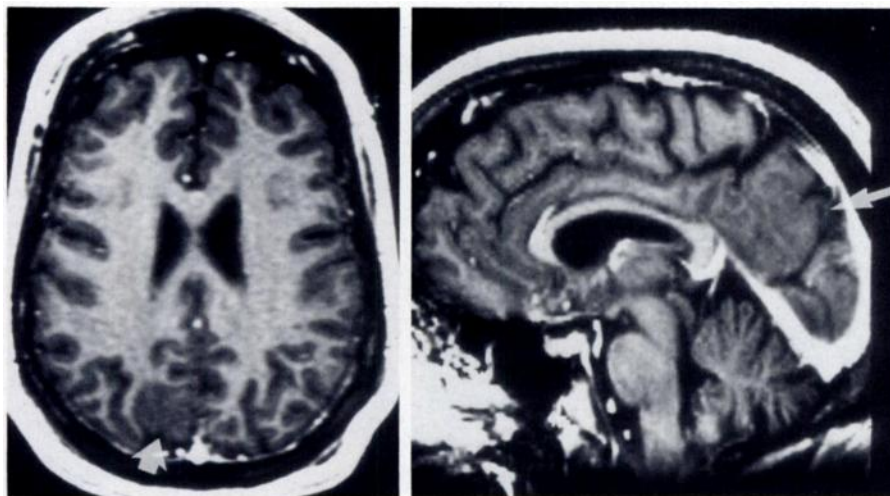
Cortical dysplasia in a 44-year-old woman with poorly controlled seizures since early childhood. MR images demonstrate an area of cortical dysplasia (arrow) in the medial right parietal lobe, which was resected stereotactically. (a) Axial three-dimensional SPGR image. (b) Reformatted off-axis sagittal image from the same three-dimensional sequence. These images demonstrate an area of cortical thickening in the right precuneus, which is clearly demarcated by the parieto-occipital sulcus posteriorly.
